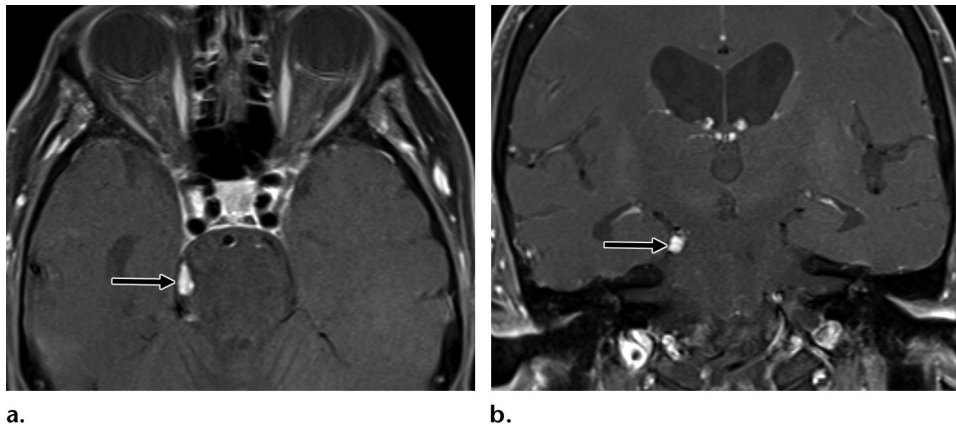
Clinically diagnosed CN IV schwannoma in an 83-year-old woman who presented with diplopia and CN IV palsy. (a) Axial contrast-enhanced fat-suppressed T1-weighted MR image shows a homogeneously enhancing schwannoma (arrow) in the ambient cisternal segment of right CN IV. (b) Coronal contrast-enhanced fat-suppressed T1-weighted MR image shows the enhancing schwannoma (arrow) in the right ambient cisternal segment, underneath the tentorium.
